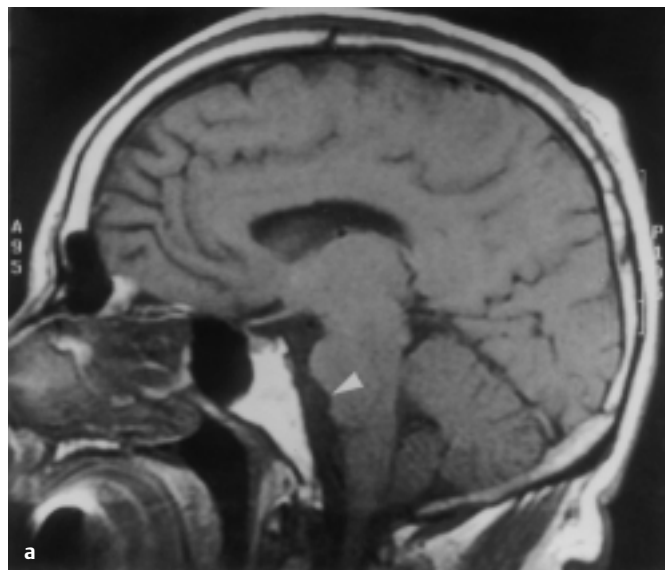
a T₁-weighted midline sagittal MRI reveals a hypointense mass (arrowhead) in the prepontine area compressing the pons. b T₁-weighted axial MRI shows the same extra-axial mass (arrowhead) in the prepontine area.
